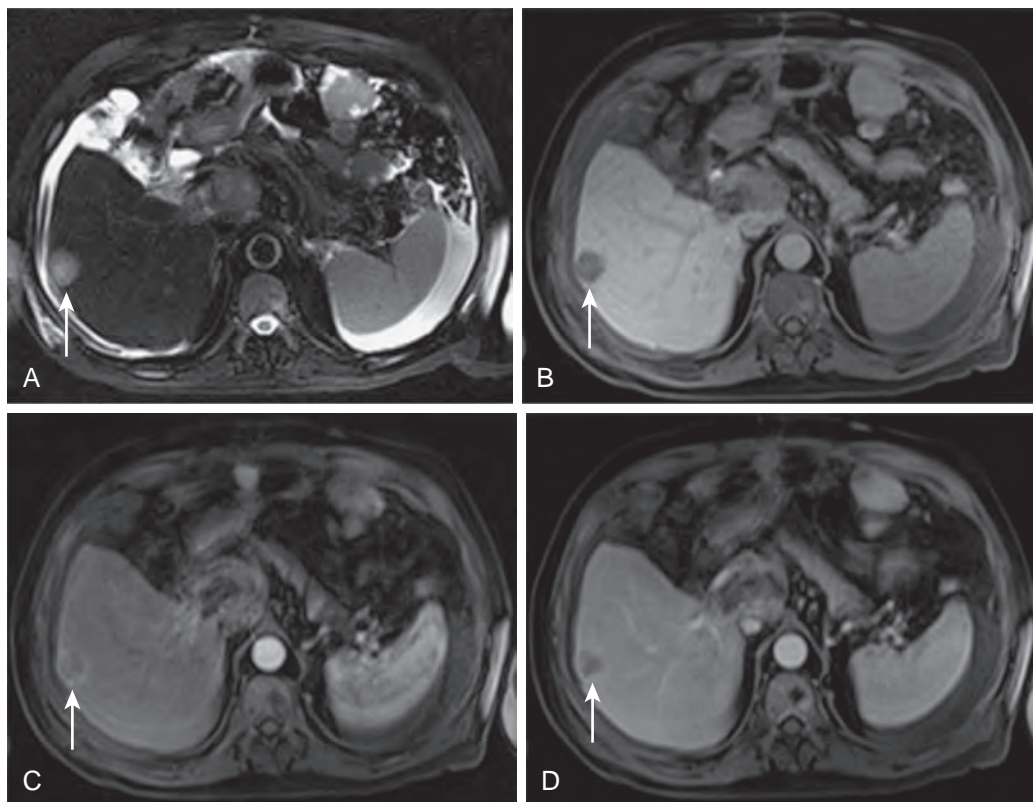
HCC (arrows): MRI findings. HCC in the right lobe of the liver that is hyperintense on the T2-weighted image (A) and hypointense on the T1-weighted image (B). It shows arterial enhancement and then washout on the arterial phase (C) and portal venous phase (D) images, respectively.
